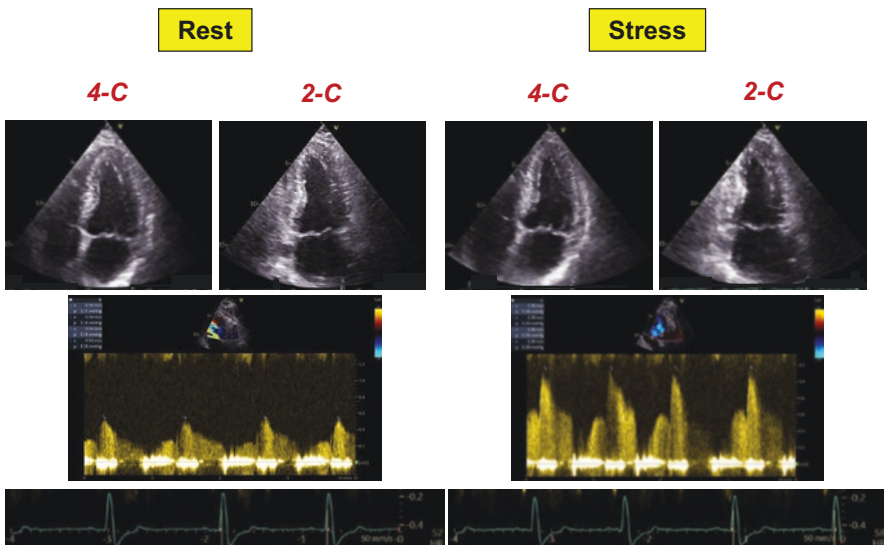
Example of wall motion, coronary flow velocity reserve, and heart rate reserve assessment in patients with normal coronary arteries. Upper panels: end-systolic frames of apical four-chamber and two-chamber views showing normal function at rest and peak stress. Middle panels: Visualization of coronary flow in the mid-distal portion of the left anterior descending artery using pulsed-wave Doppler. Peak diastolic flow velocity was 54 cm s^{-1} under basal conditions (middle left panel) and 116 cm s^{-1} after dipyridamole infusion (middle right panel), with a normal CFVR value of 2.15. Heart rate reserve (lowest panels) is abnormal (rest = 52 beats/min; peak 58 beats/min; heart rate reserve = $58/52 = 1.11$, normal values >1.22). (Courtesy of Dr. Lauro Cortigiani)
